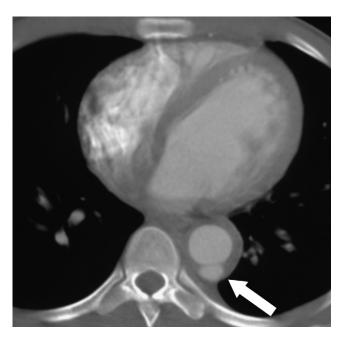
Contrast enhanced CT scan of the thoracic aorta at the level of the left ventricle. There is circumferential thickening of the aortic wall with areas of ulceration (white arrow).
